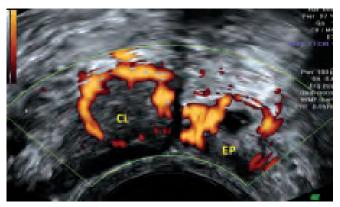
Transvaginal power Doppler of tubal ectopic pregnancy (EP) and ipsilateral corpus luteum (CL)
